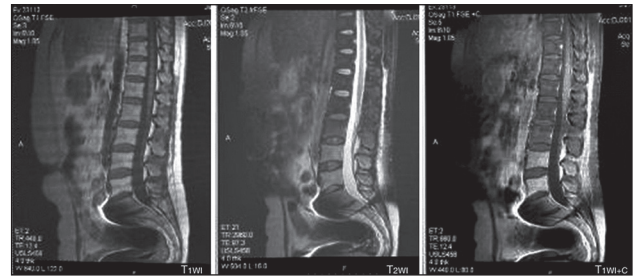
A spinal cord magnetic resonance imaging scan showed disappearance of thoracolumbar lesions
